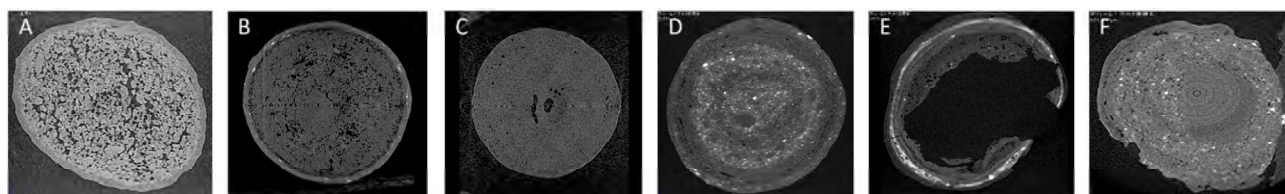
Microfocus X-Ray Computed Tomography (CT) Cross-Sectional Image of Intracapsular Granules with Poor Dissolution in Omeprazole Enteric-Coated Capsules
